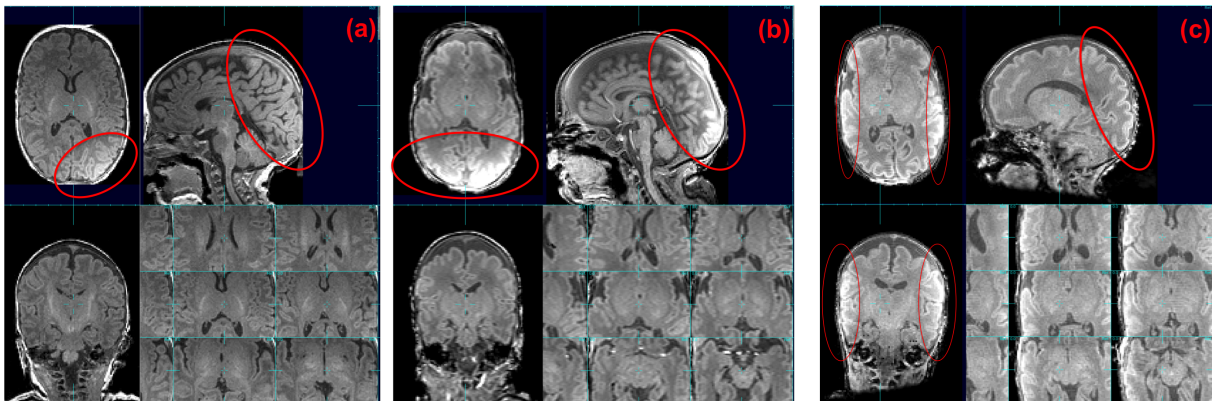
Three examples of bias-corrupted premature neonatal MRI with different levels and features of bias artifact. Red circle: abnormally high intensity caused by bias artifact.
